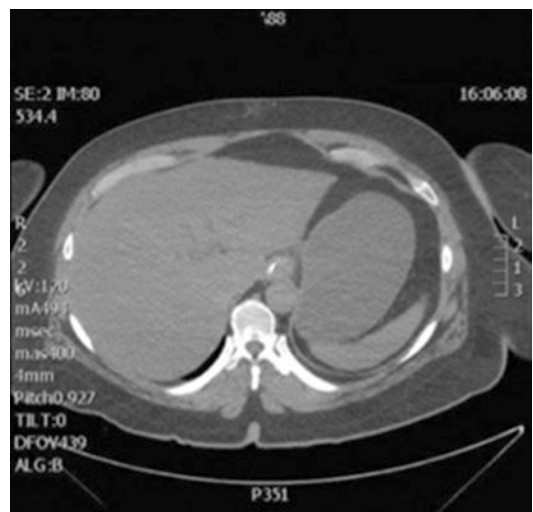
CT scan showing a gastric remnant filled with blood secondary to an intraluminal bleeding after gastric bypass
